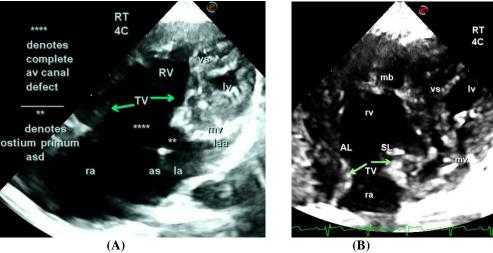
Complete atrio-ventricular canal defect (CAVCD). (A) Apical 4C view from right chest discerns the ostium primum ASD ()and CAVCD (); (B) Apical 4C view from right chest portrays common AV valve with two components: large anterior and septal leaflet of TV and bileaflet MV; mv, mitral valve; lv, left ventricle; vs, ventricular septum; mb, moderator band ; rv, right ventricle; ra, right atrium; AL, anterior leaflet of TV; SL, septal leaflet of TV; as, atrial septum; TV, tricuspid valve.
